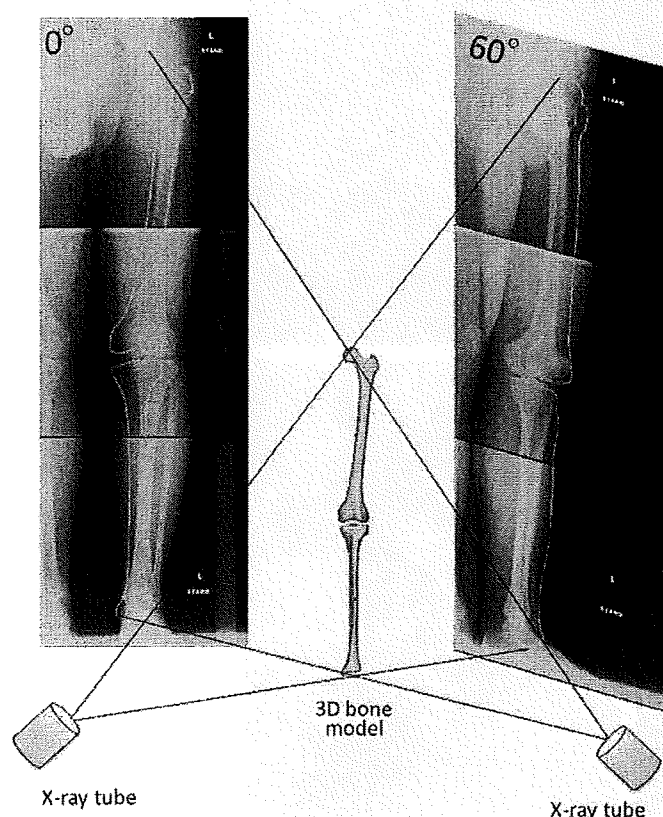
Synthetic biplanar X-ray system. Projected outline points of each 3D model were the finite edge points of the 2D shadow created from the projections of all visible triangular surfaces of the 3D model.
